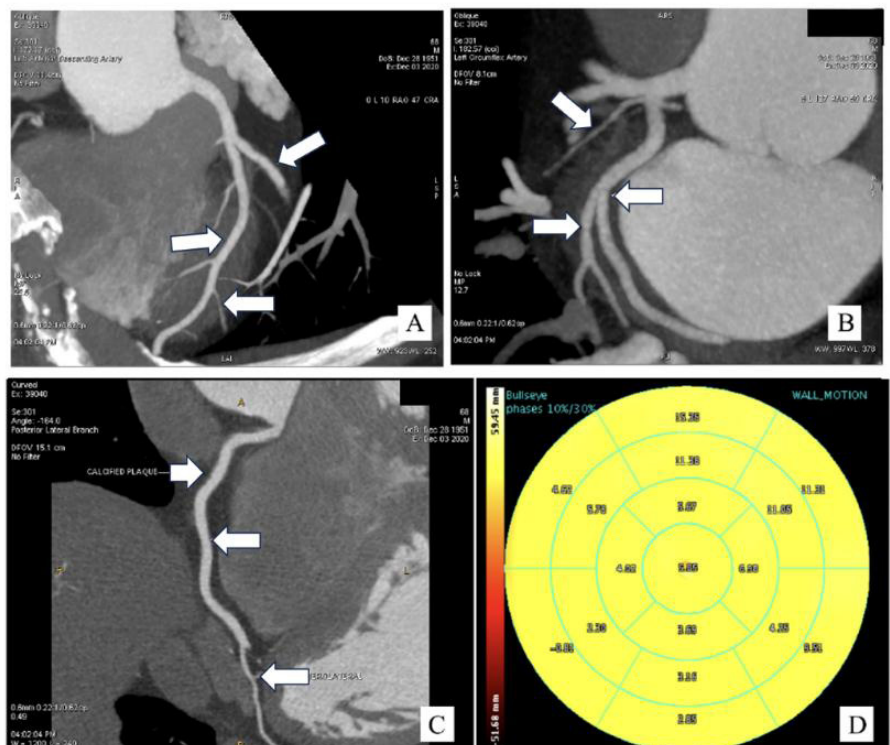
CT angiography showing mild calcified plaque in the middle segment of right coronary artery (RCA) (white arrow).
